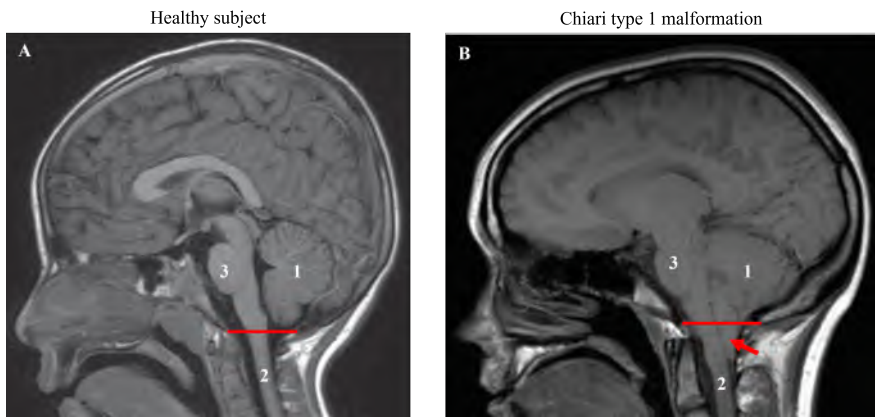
Sagittal MRI of the head with (1) cerebellum, (2) spinal cord, and (3) brainstem of (A) healthy subject (image adapted from Netter et al. [12]) and (B) patient with Chiari type 1 malformation (image adapted from Zisakis et al. [54]) depicting the herniated tonsils with red arrow.
